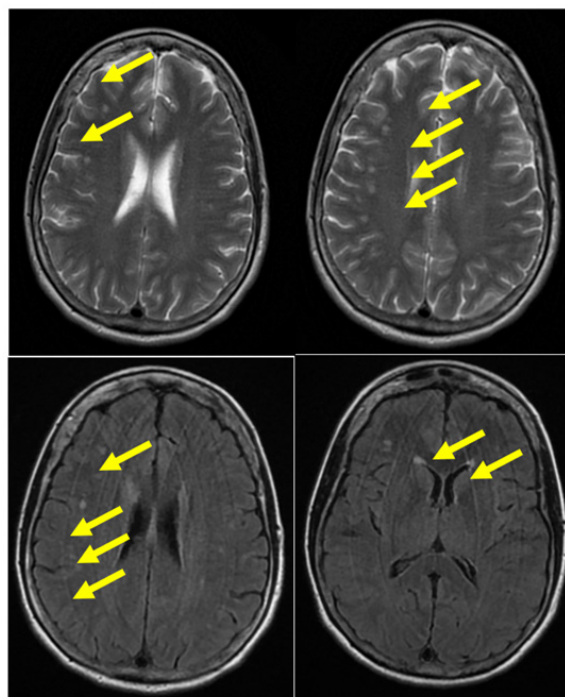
MRI with contrast.
